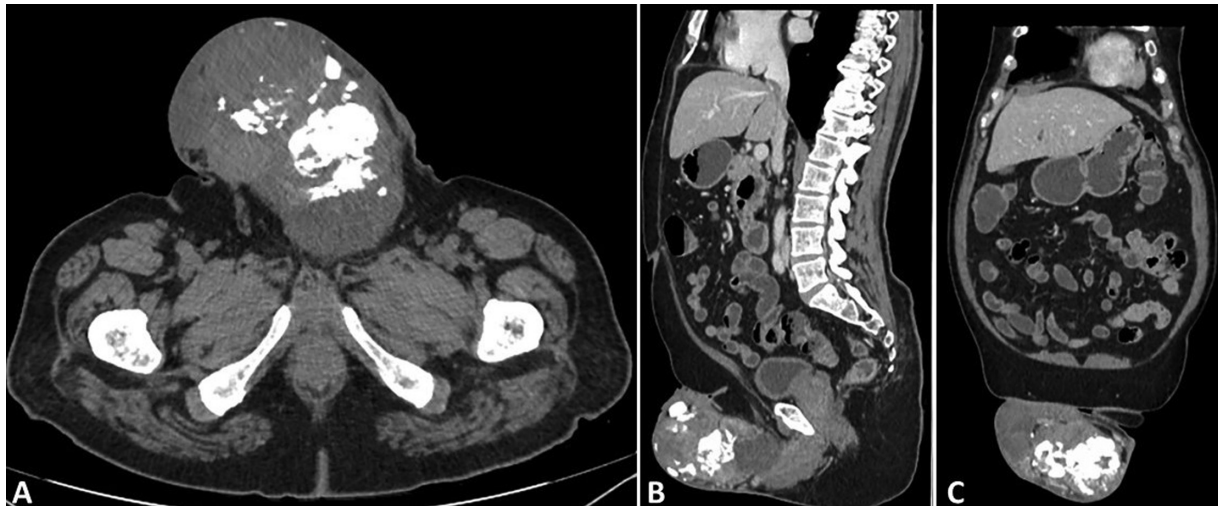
Computed tomographic images showing a large left paratesticular tumor with extensive amorphous calcification. (A) Cross-sectional imaging, (B) sagittal image, and (C) coronal image through the tumor.
